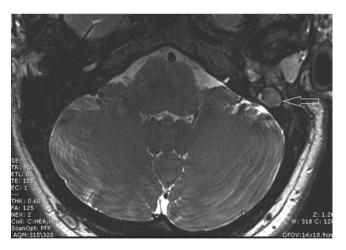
A T2 MR image of a left ear with residual cholesteatoma adjacent to the posterior fossa dura (*white arrow*). (Copyright held by Dennis S. Poe, MD, PhD, Boston Children's Hospital)
